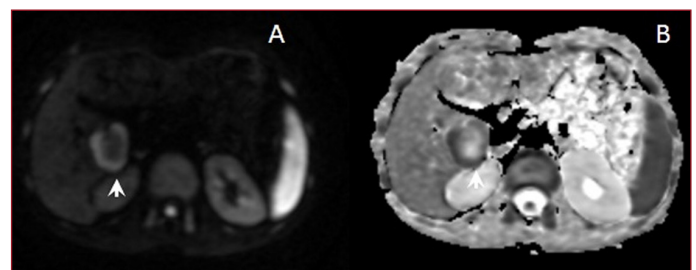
In the metastatic mass lesion observed in liver parenchyma, A) Target sign appearance with a hypointense center and a hyperintense circular periphery in DWI; B) In contrast to DWI, target sign appearance with a circular hypointense periphery and a hyperintense center in an ADC map passing through the same section
